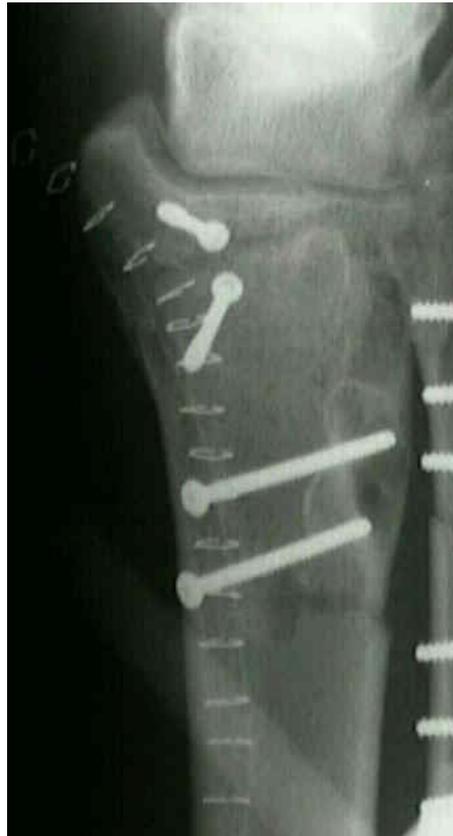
Radiography after the surgery
